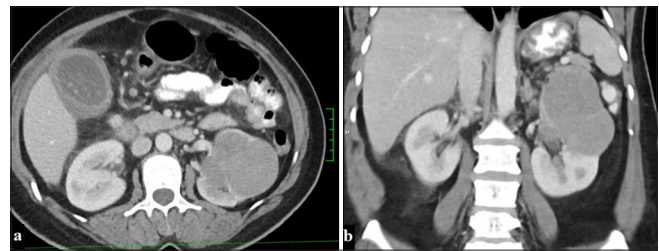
A 53-year-old woman with a mass lesion in the upper pole of the left kidney, displaying macrolobulated contours and minimal contrast enhancement in the portal phase on (a) axial and (b) coronal planes on CT (Chromophobe renal cell carcinoma).
